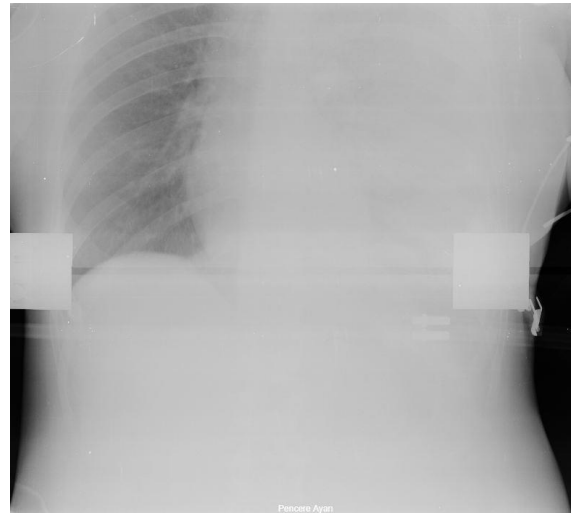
Chest x-ray at the presentation of the patient
